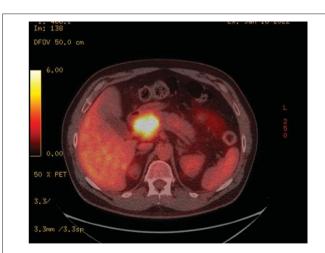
PET/CT Scan showing intense avidity at the pancreatic head, with periportal lymphadenopathy. SUV of pancreas head mass 10.1 compatible with malignancy.
